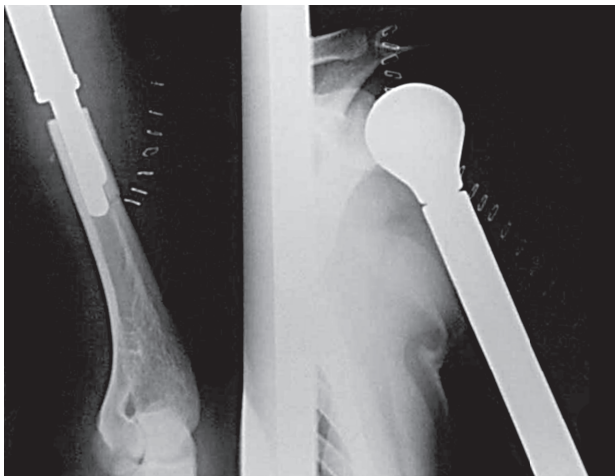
Postoperative plain radiographs.
